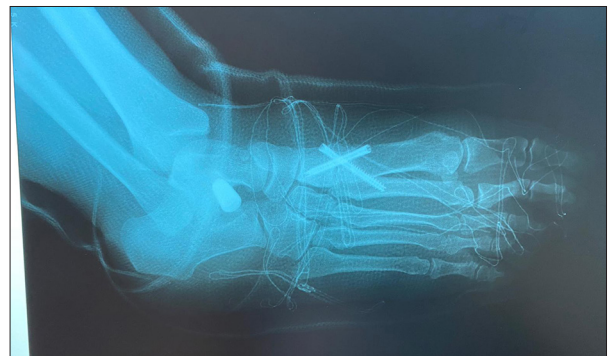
Postoperative X-ray. Oblique plane.
